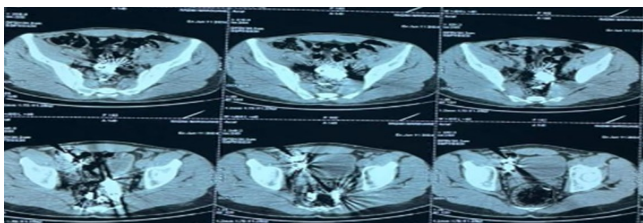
Pelvic CT scan showed multiple spontaneously hyperdense formations.
